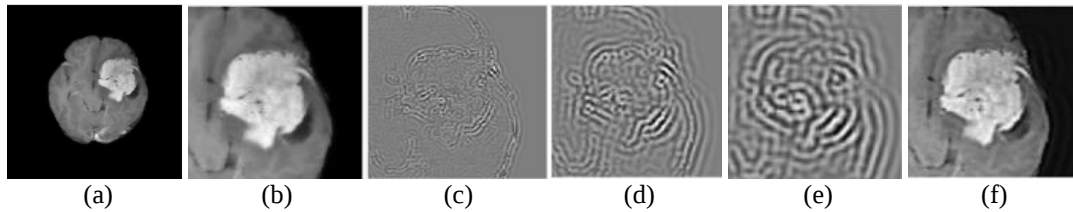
Input MRI for VGG19 feature extraction: (a) enhanced MRI (512×512), (b) tumor ROI (224×224), (c) $BIMF_1$ of ROI with noise, (d) $BIMF_2$ of ROI (ROI_1), (e) $BIMF_3$ of ROI (ROI_2), and (f) RGB integrated ROI, ROI_1 , and ROI_2 . (note: Figure 5(b) and Figure 5(f) serve as inputs for feature extraction)
